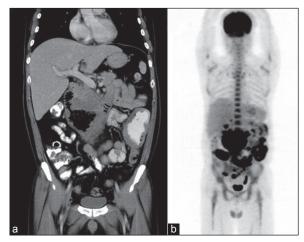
(a) Computed tomography of abdomen (coronal view) showing diffuse lobulated intestinal wall thickening over the second, third and partial fourth portion of duodenum, distal jejunum and proximal ileum with multiple enlarged lymph nodes in the adjacent small bowel mesentery, hepatoduodenal and para-aortic spaces. (b) Whole body positron emission tomography scan showing several fluorodeoxyglucose-avid lesions within abdomen, including mid abdomen (>12 cm), right lower quadrant (>6.0 cm), left lower quadrant (>7.0 cm) and also several smaller ones at different sites involving the bowel loops
